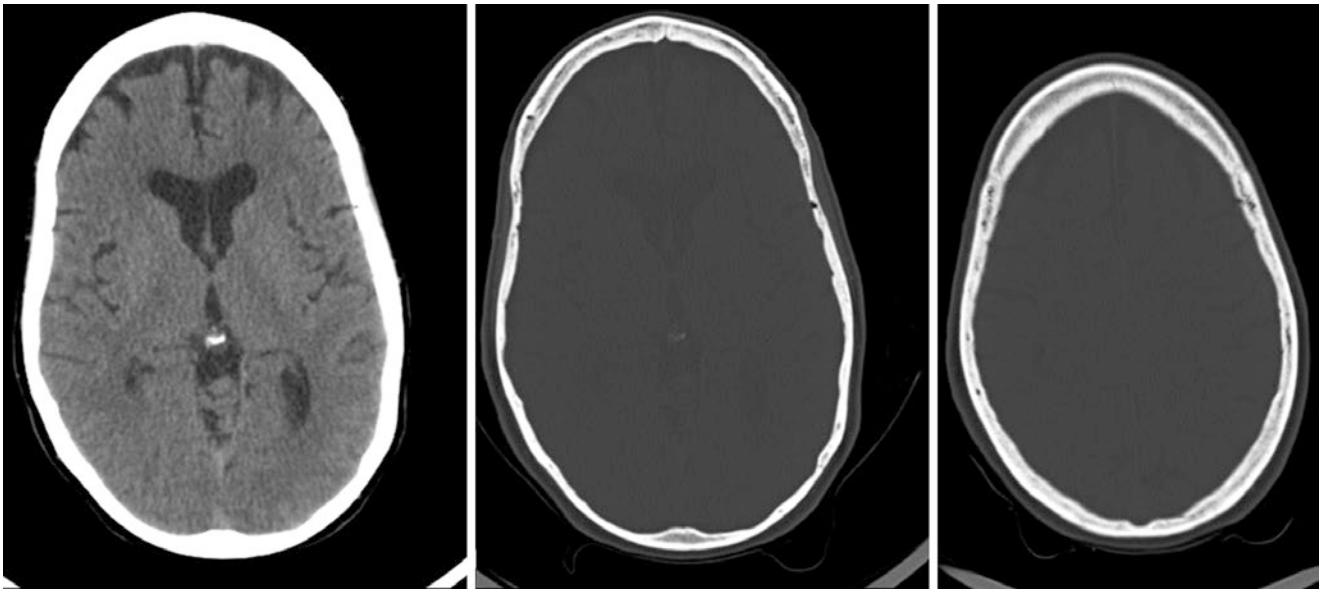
In a 62 year old a CT scan was ordered to evaluate for hemorrhage after trauma in a previously asymptomatic patient. Note the scaphocephalic shape. There was no intracranial hemorrhage or fracture. No congenital-genetic history was present
